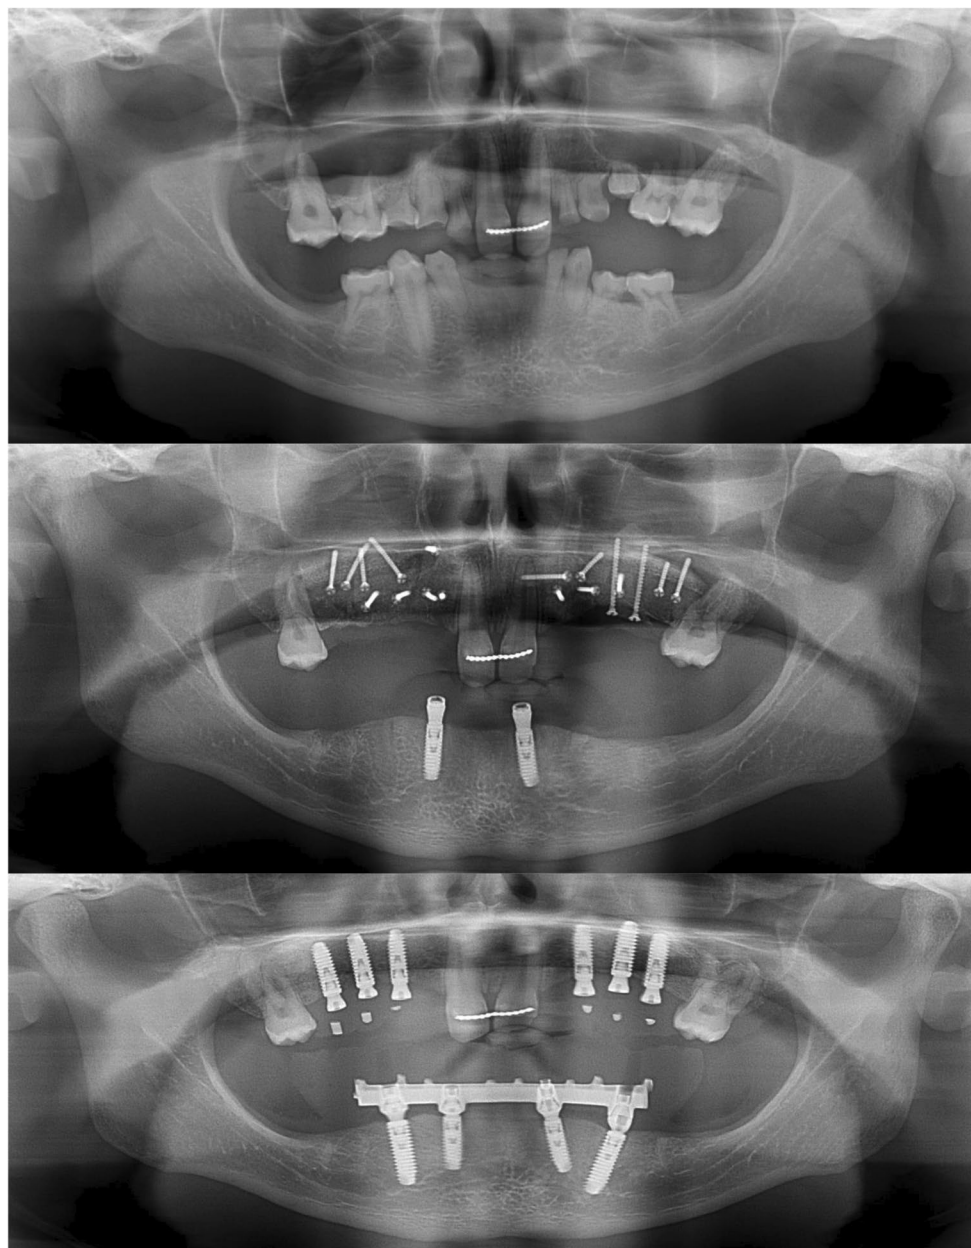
(A) Panoramic radiograph of a patient at the age of 16.5 years with 23 missing permanent teeth. (B) Panoramic radiograph at 18 years after Le Fort I procedure, bone grafting, bilateral IAN lateralization, and placement of six mandibular implants
